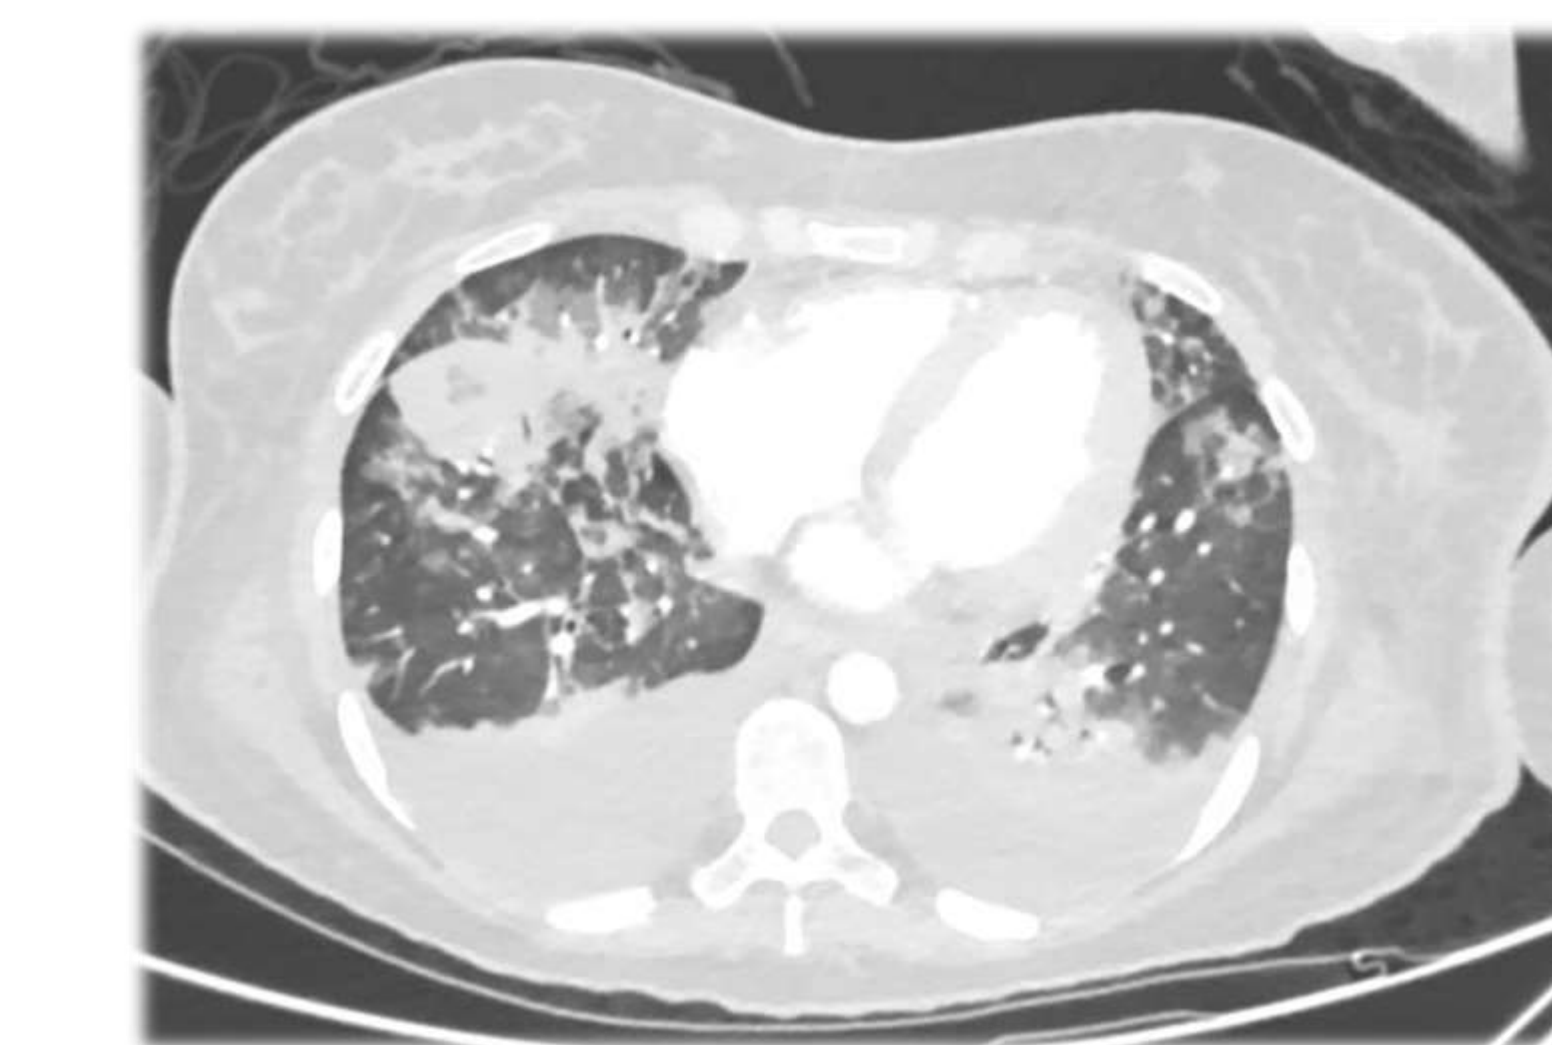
Chest CT scan from patient with IA. We can observe a large nodule and cavity lesion in the right lung, multiple nodules, and ground glass opacities.
